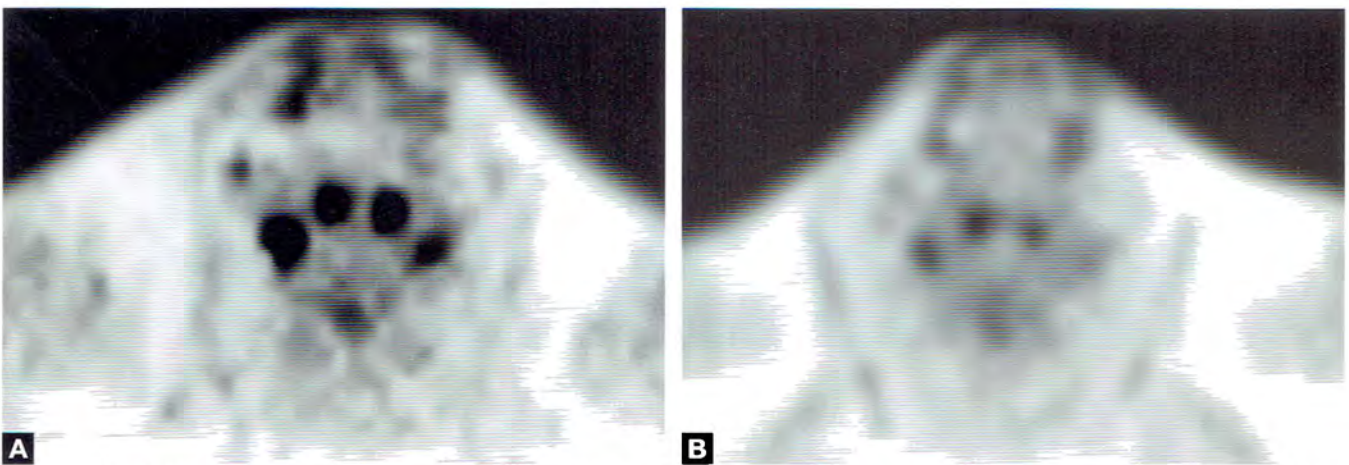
Hypermetabolic bilateral supraclavicular activity is seen in the first image. This pattern is consistent with brown fat activation. The second image is from a subsequent FDG PET/CT which no longer demonstrates the brown fat activation.
